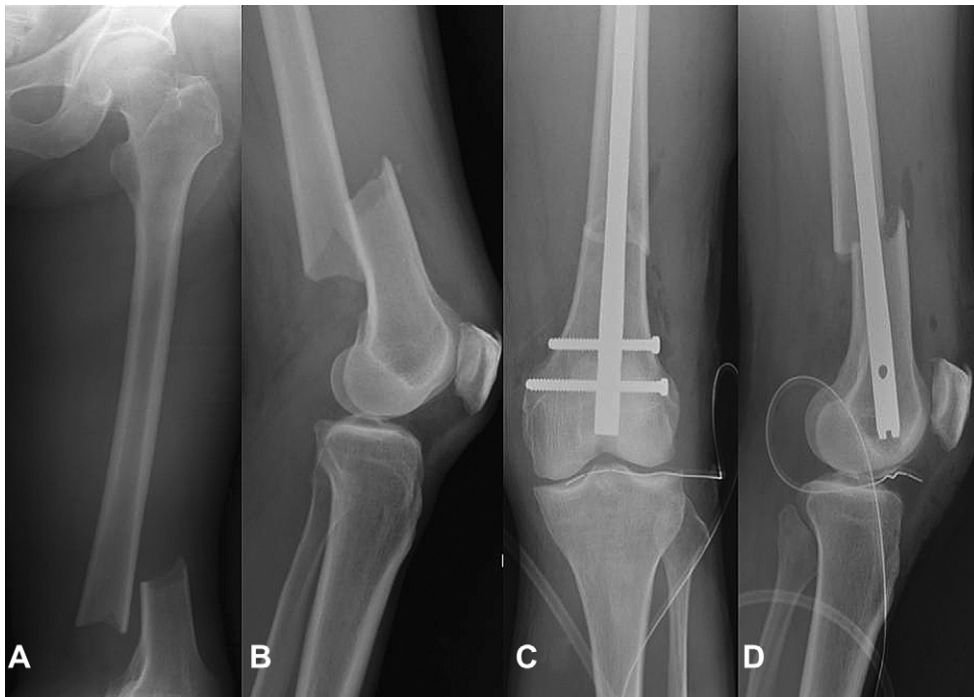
(A) and (B) Radiographs of the fractured distal femur showing a severely angulated and posteriorly translated transverse fracture noted before operation; (C) and (D) after closed reduction and retrograde intramedullary nail fixation, the fracture was restored with suboptimal alignment for residual translation, but no abnormal soft tissue mass was observed at this time.
